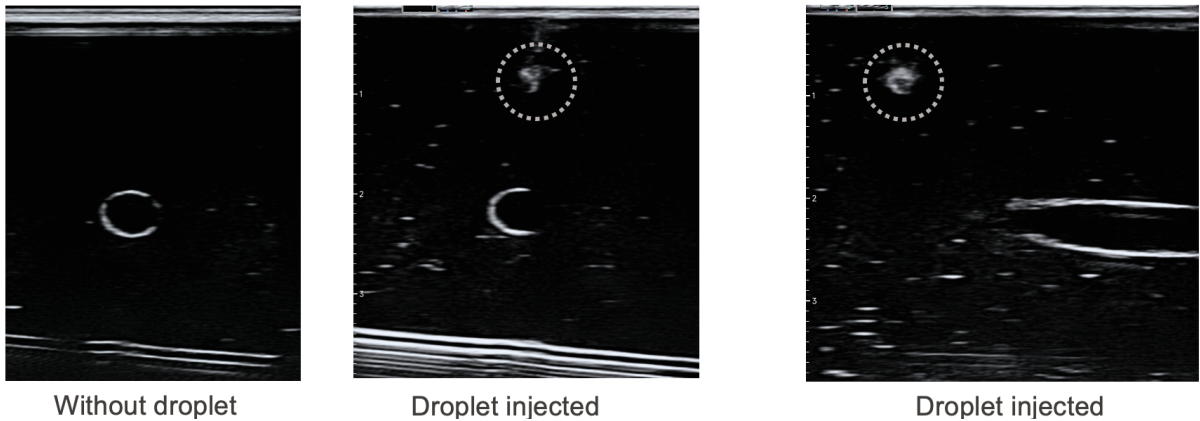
Ultrasound imaging comparison demonstrating contrast enhancement by cavity-containing hydrogel microdroplets. Left: baseline image without droplets showing minimal contrast. Center and right: images after droplet injection, showing bright hyperechoic signals (circled) corresponding to the cavity-containing microdroplets, which provide strong acoustic scattering for enhanced visualization.
